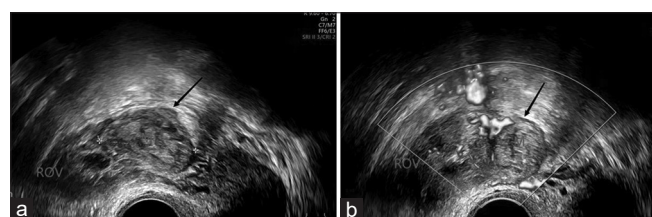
(a) Pregnancy in the right adnexal area (arrow) by transvaginal ultrasound. (b) Color Doppler flow imaging (CDFI) shows blood flow signals within the mass (arrow). ROV: Right ovary
